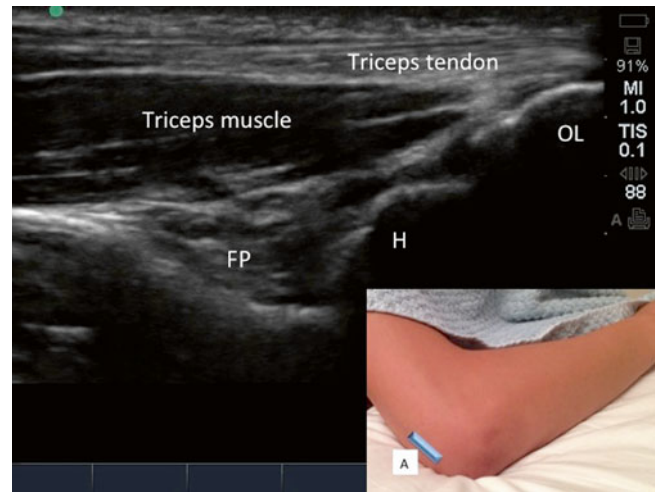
Sonogram of the elbow joint viewing from the posterior aspect. The position of the elbow and the ultrasound probe is shown in the inset. OL olecranon, FP fat pad in the olecranon fossa, H humerus (Reproduced with permission from Philip Peng Educational Series)
